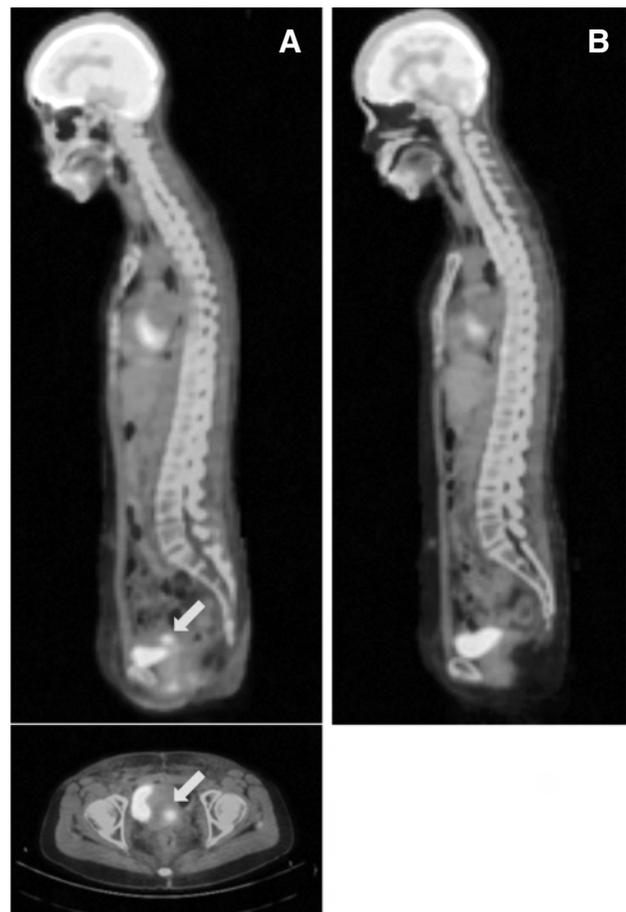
FDG PET/CT fusion images obtained at the time of the diagnosis of condyloma acuminata (A), and six weeks after eradication of the condyloma acuminata (B).
